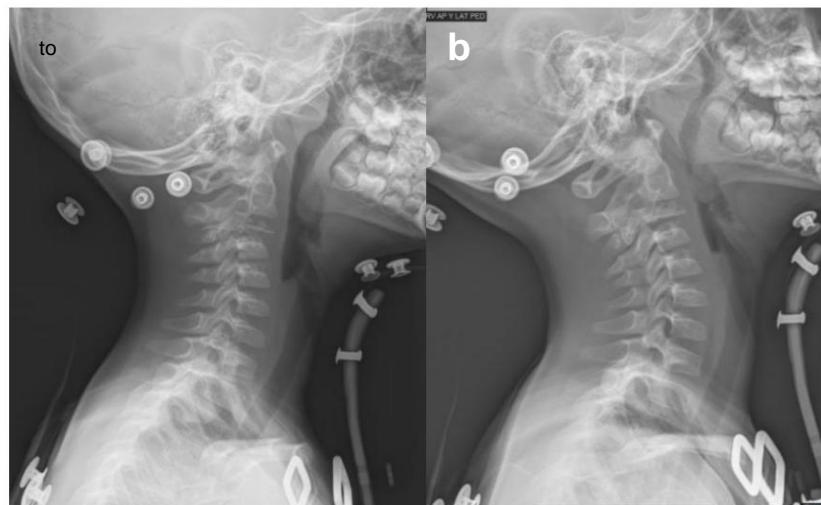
Lateral X-ray of the cervical spine with adapted orthosis (a) and control at two months (b): the restoration of the physiological cervical lordosis and a progressive recovery of the height of the C3 vertebral body can be seen.
